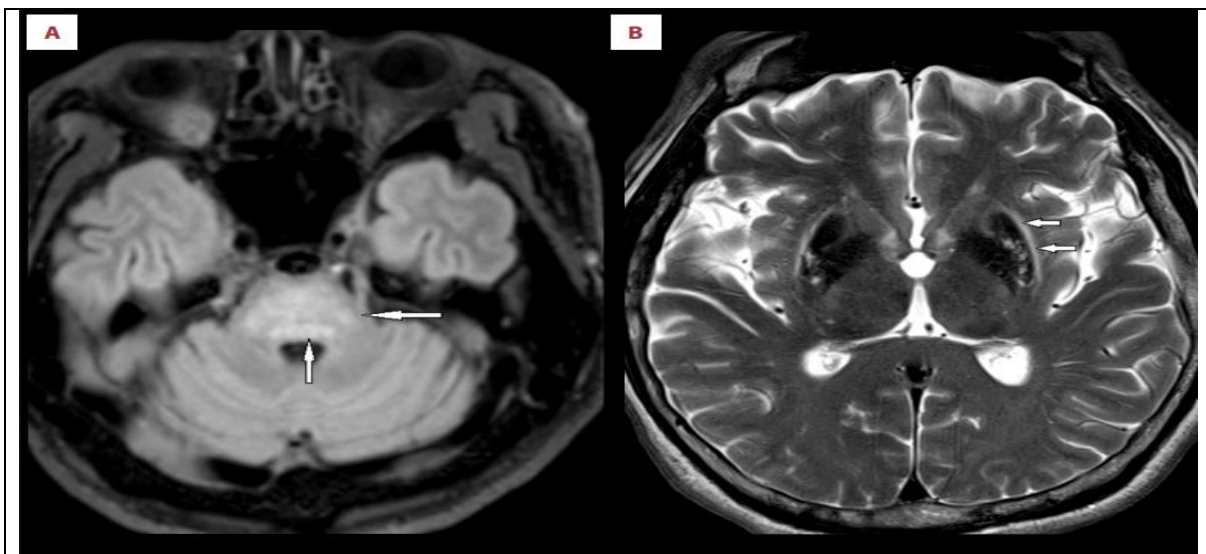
Brain magnetic resonance imaging. Axial FLAIR sequence (A) shows diffusely enhanced signal (white arrows) across the pons, while axial T2 sequence (B) shows mixed signal in the lentiform nuclei and increased signal (white arrows) in the external capsule.
